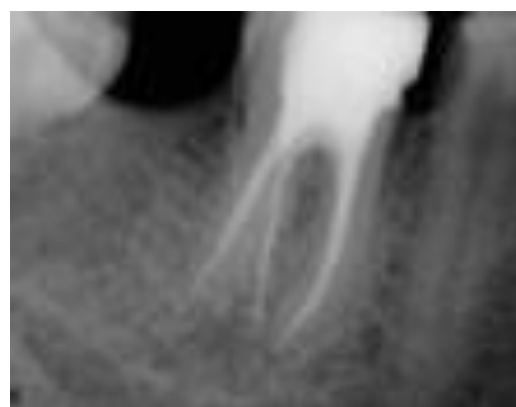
Obturation radiograph
